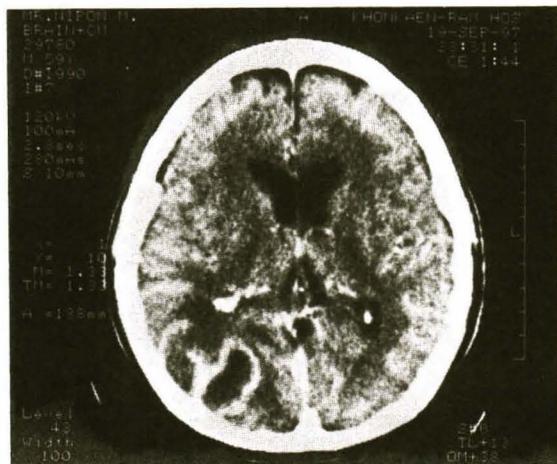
CT scan of the brain with contrast enhancement showing an abscess at the right parieto-occipital region.
